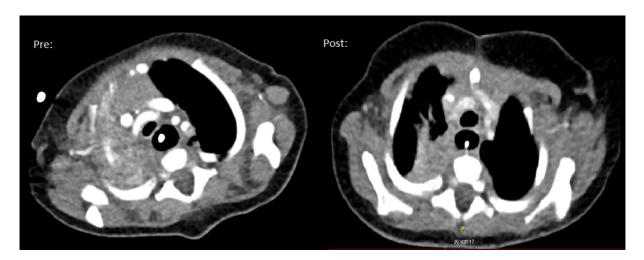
Pre and postoperative computed tomography scans of a patient with tracheobronchomalacia. Left: preoperative scan showing a malatic trachea with a diameter of 3mm at the origin of the brachiocephalic trunc. Right: Postoperative scan of the same patient showing an increase of the tracheal lumen diameter after aortopexy.
